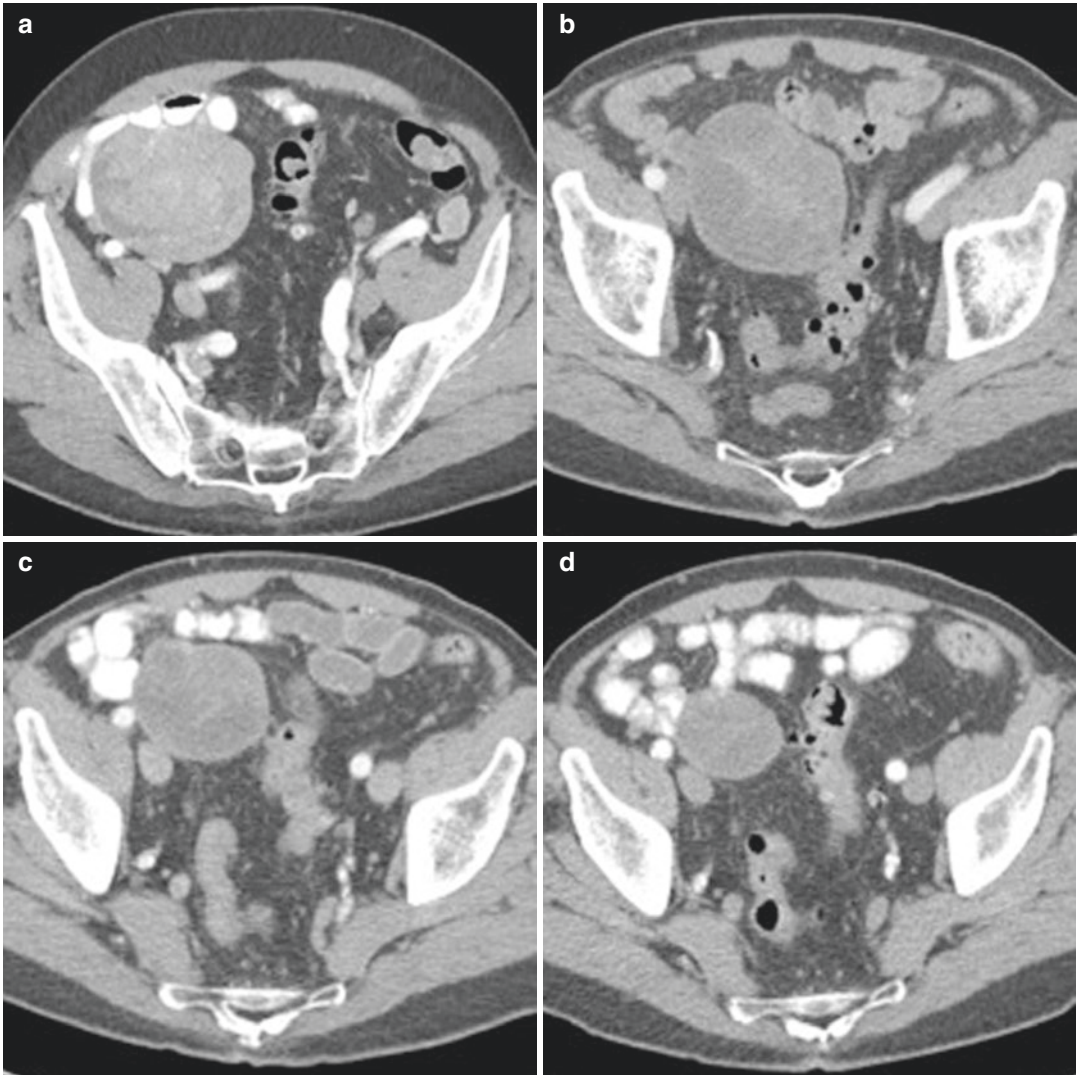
A patient with incidentally diagnosed small bowel GIST with peritoneal metastases. (a) On initial axial contrast-enhanced CT image, the primary tumor in the right lower quadrant measures 8.4 cm in the longest dimension, and 92 HU. (b) Axial contrast-enhanced CT 2 months after the initiation of imatinib. The mass is unchanged in size (8.3 cm) but decreased in attenuation to
